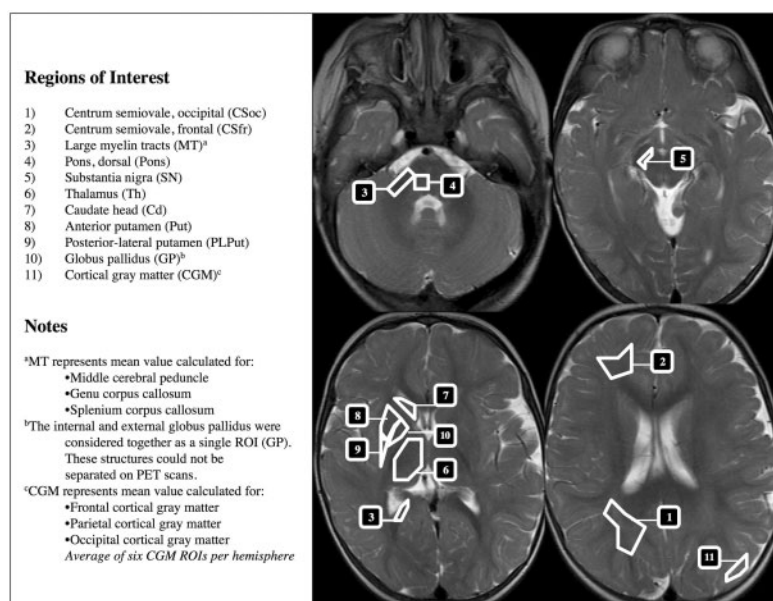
Region of interest scheme. Modifications were used for ADC, FDG PET and perfusion CT studies.
